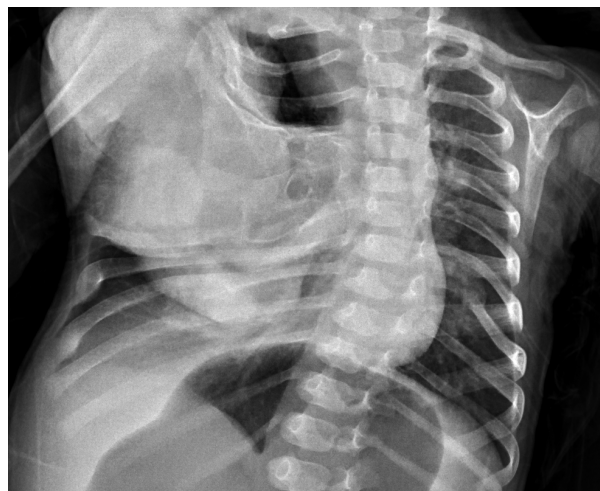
Chest-x-ray shows a large well-defined soft tissue mass in chest wall in right side with deformity of the adjacent ribs and mediastinal shift to the left.
